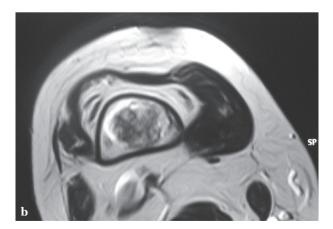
Coronal T2-weighted MR image of the right distal femur, showing an intramedullary, lobulated heterogeneous lesion with high and low signal intensities.
